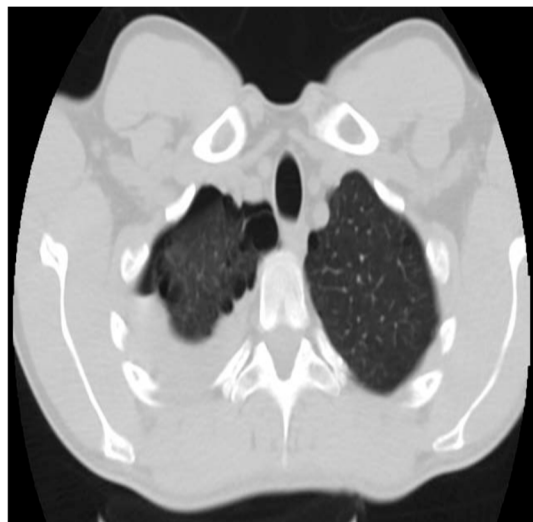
Native chest CT. Moderate right hydropneumothorax with gas bubbles inside and pulmonary condensation of the right lower lobe with air bronchogram and bilateral subpleural emphysema bubbles between 8-25 mm in size.
